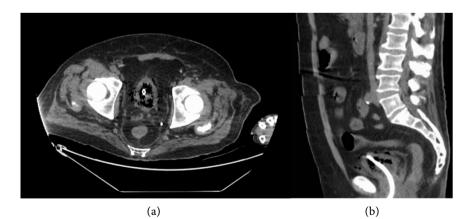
(a) Pelvic CT scan in axial section showing the presence of intraluminal, intraparietal, and perivesical gas bubbles. (b) Abdominopelvic CT scan in sagittal section showing a gas density image in the lumen, the wall of the bladder with gas diffusion in the perivesical spaces.
